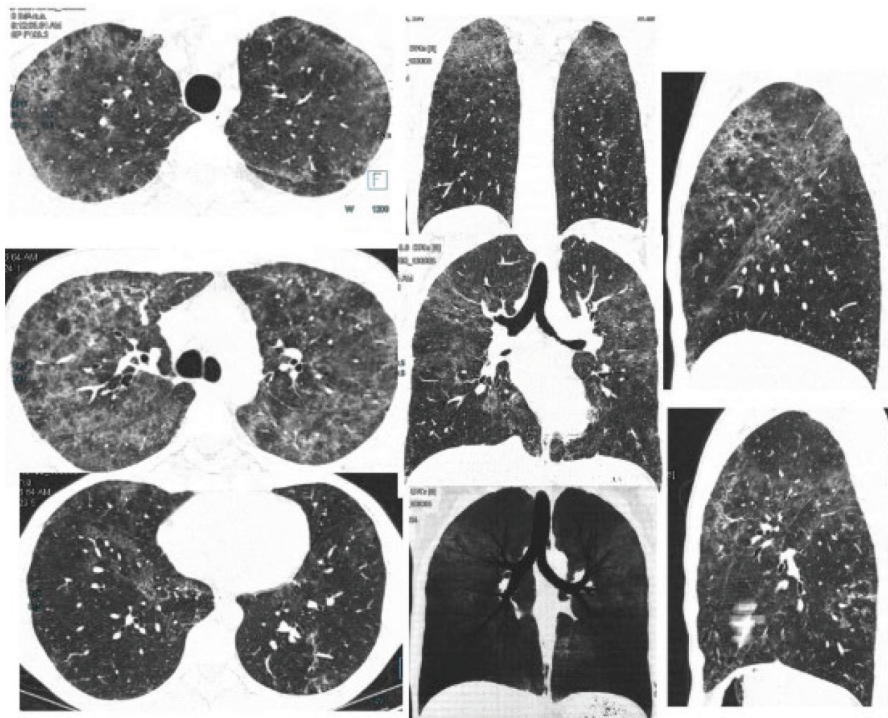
Transverse, coronal (MPR and MinIP) and sagittal high-resolution CT performed 3 months after the initial episode of dyspnoea showing subpleural and central ground-glass opacities in both lungs, predominantly in the upper lobes, with septal thickening, intralobular lines and distortion without microcysts (pattern suggests NSIP). Consolidations of the lower lobes have disappeared. CT, computed tomography; NSIP, non-specific interstitial pneumonia.
